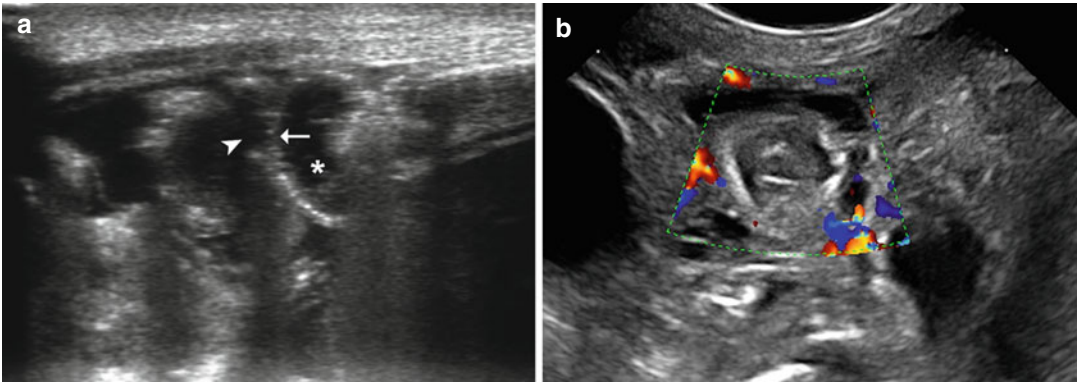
Ultrasound in newborn with NEC. (a) Wall ischemia with wall thinning (*white arrow*), perivisceral fluid (*white arrowhead*), and endoluminal fluid (*asterisk*).
